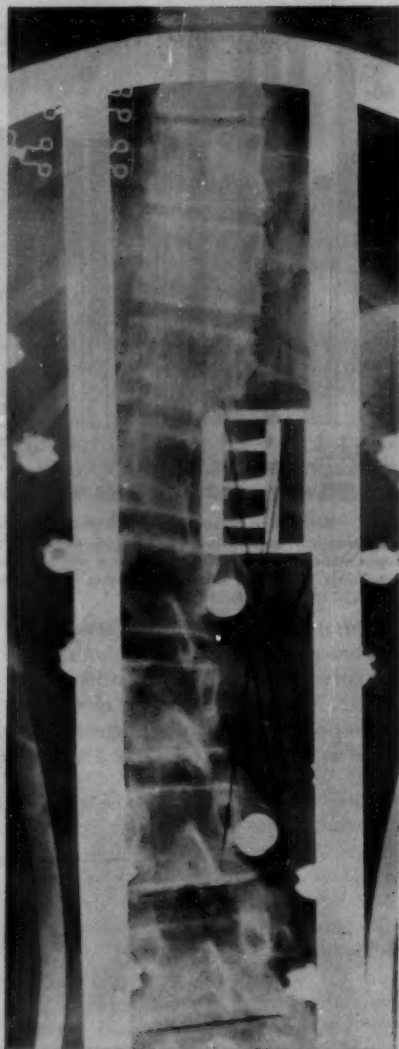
X-ray of spine of patient in figures 4 and 5 supported by brace plus puller.
